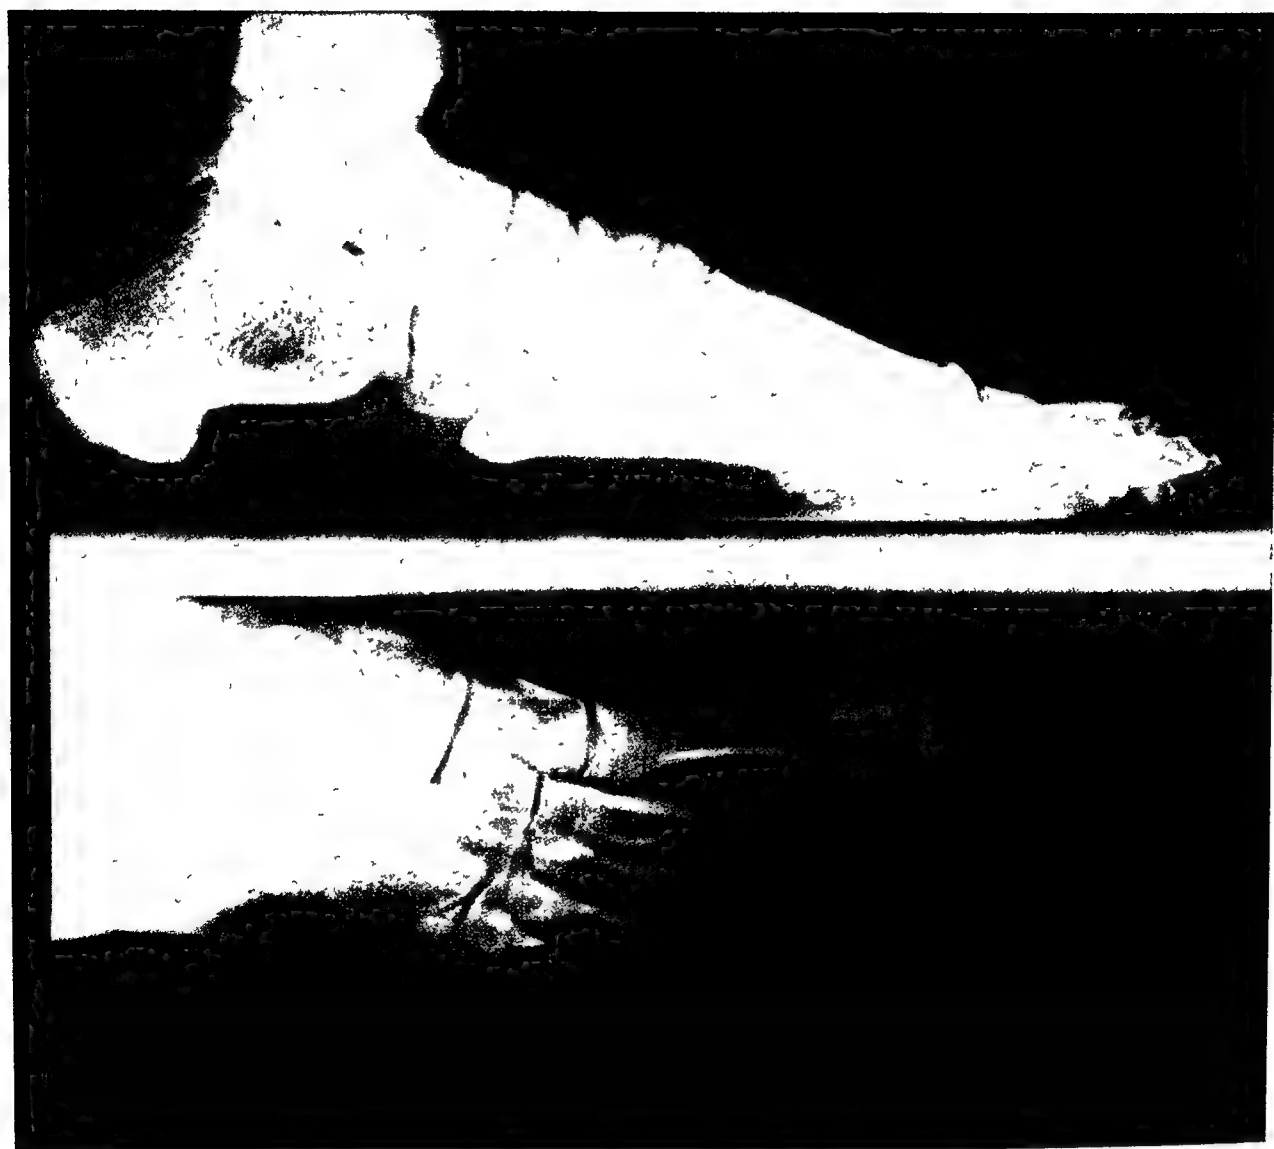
STEREOSCOPIC VIEWING (WHEATSTONE PRINCIPLE) (B) Radiograph illuminated for left eye (B') Radiograph illuminated for right eye
